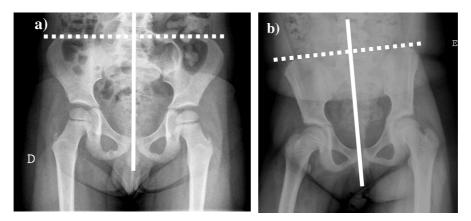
Examples of correct (a) and incorrect (b) hips radiographic positioning.
